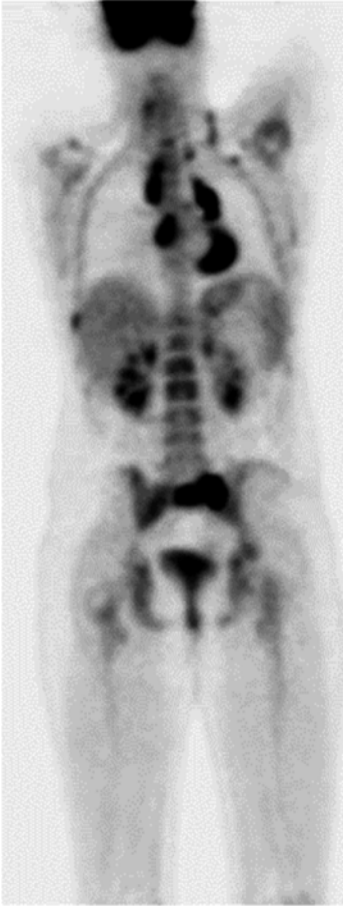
The initial PET/CT showed hypermetabolic activity in the left tonsil (not evident on this figure), the supraclavicular lymph nodes bilaterally, the mediastinum, the ninth right rib, the abdominal cavity, and the sacrum
